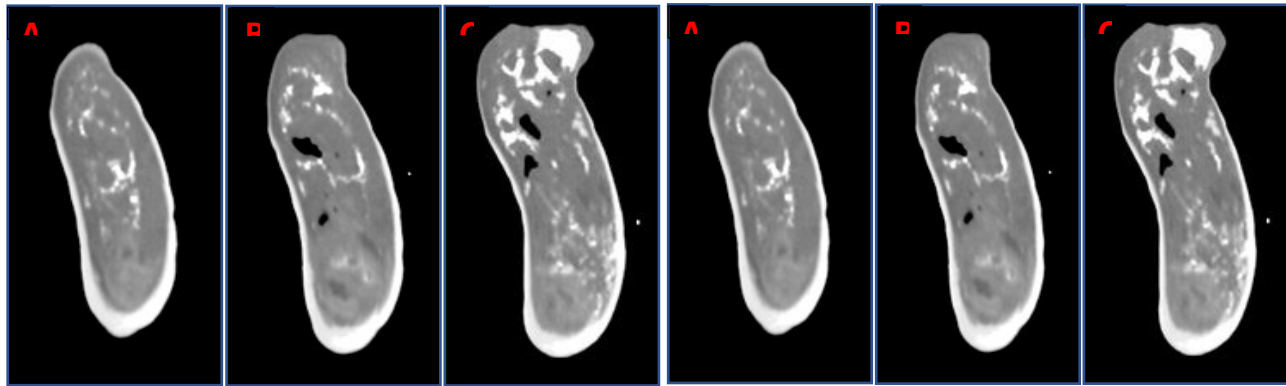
CT images (sagittal slices) of cancerous horn showing hyperdense osteolytic bony core fragments at the base of horn and pneumatic cavity with heterogeneous greyish pattern and osteolysis of bony core.
